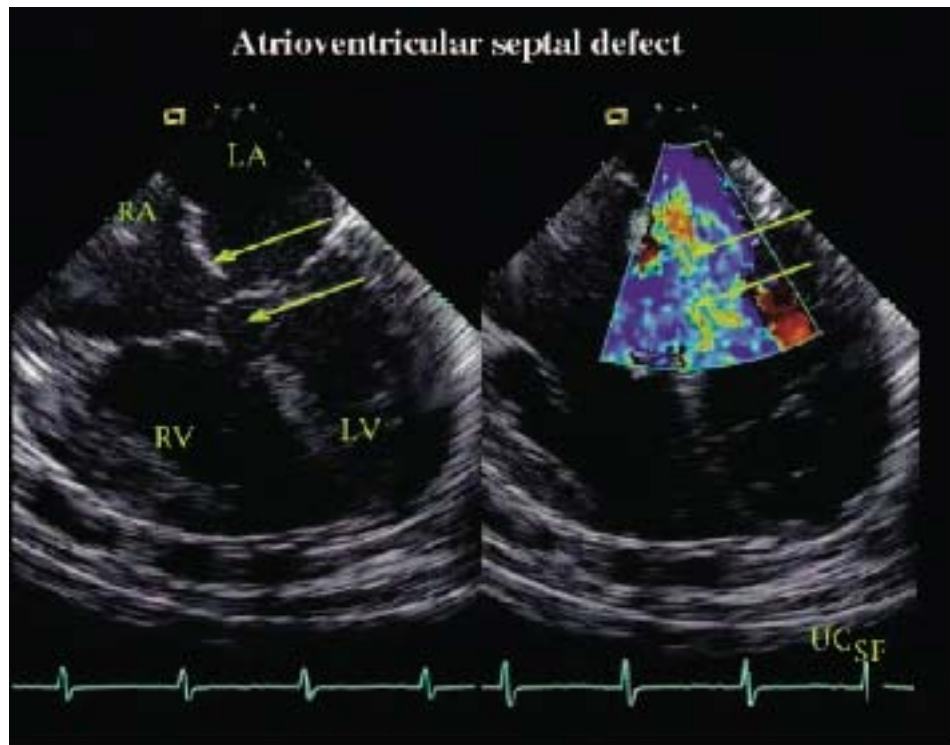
Complete Atrioventricular Septal Defect. Left: Mid-esophageal four-chamber view demonstrating a complete atrioventricular septal defect. The malformations characteristic of this lesion are shown, namely a primum atrial septal defect at the inferior aspect of the interatrial septum (upper arrow) and the posteriorly located, inlet-type ventricular septal defect (indicated by the lower arrow). Bridging of the common atrioventricular valve over the ventricular septum is seen. LA = left atrium; LV = left ventricle; RA = right atrium; RV = right ventricle. Right: Color flow Doppler showing extensive left-to-right atrial and ventricular level shunting.
